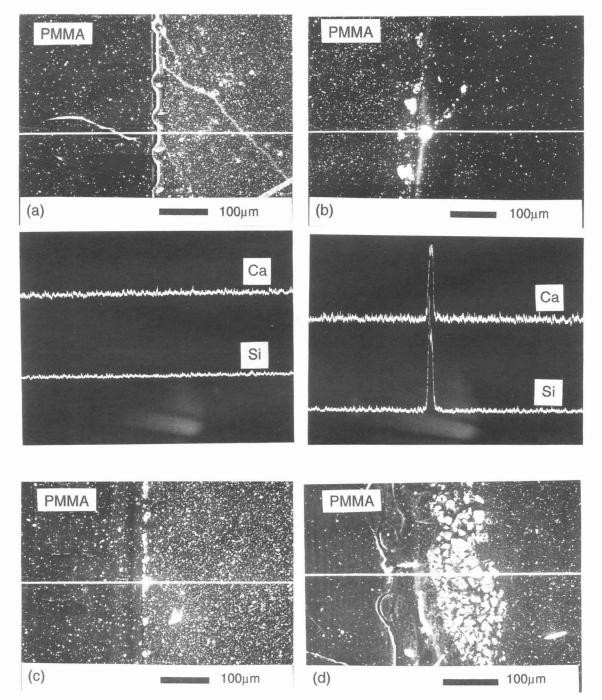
SEM photographs of cross section of ultrasonically implanted PMMA.1000mg glass/40ml solution. THF:ethanol= (a)7:3, (b) 6:4, (c) 5:5, (d) 4:6., Corresponding Ca and Si distributions after electron probe micro line-analysis are also indicated.
